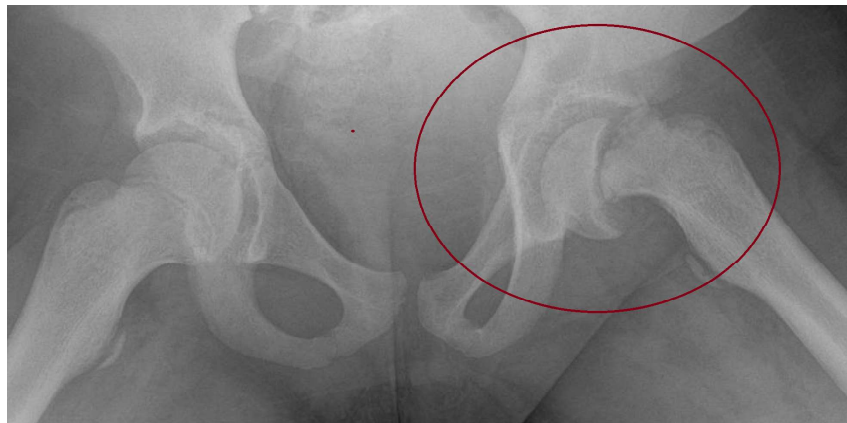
Frog-leg lateral radiographic view of the bilateral hips in a patient with Down syndrome, demonstrating a left slipped capital femoral epiphysis.
